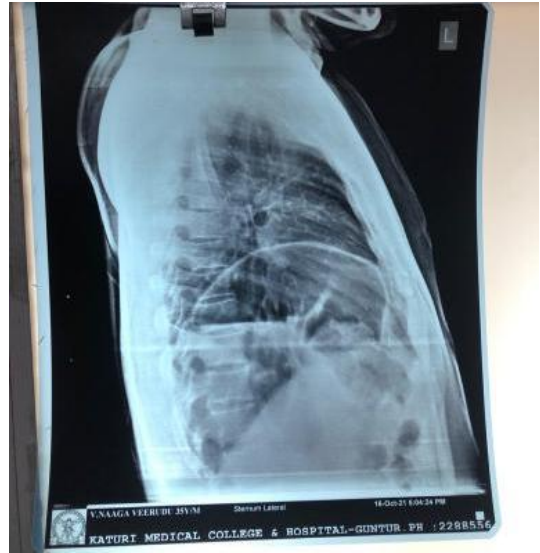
Chest X-ray left Lateral view: elevated left dome of diaphragm with fundic gas bubble visible in the mediastinum
